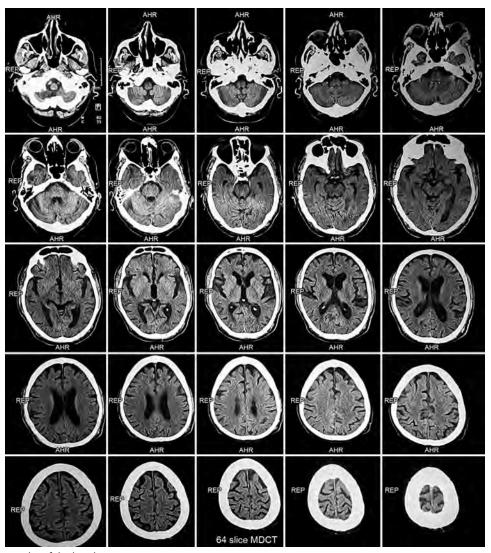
Computed tomography of the head
